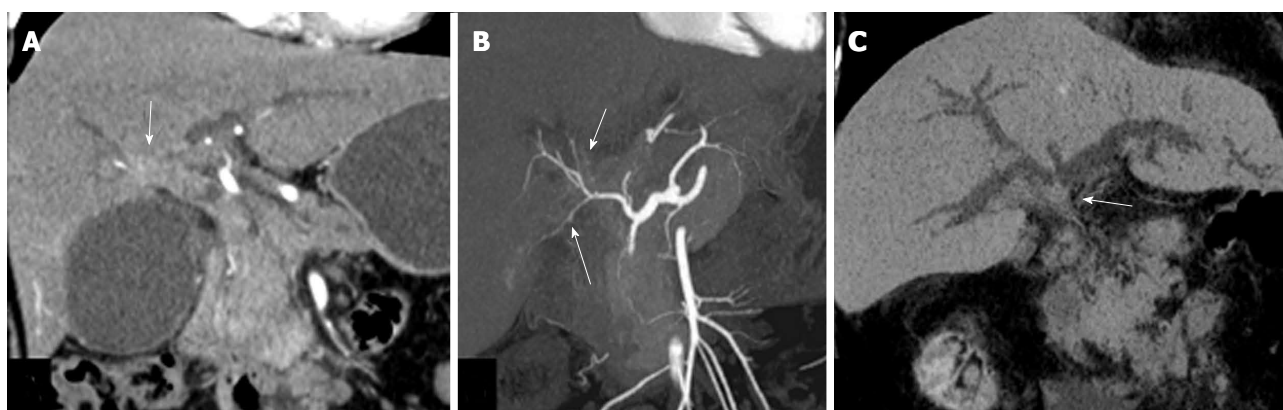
Post processing of computed tomography scan. A: Coronal reformat showing ill-defined enhancing mass (arrow) in relation to hilum and common hepatic duct; B: Coronal thick maximum intensity projection showing same mass as in A (short arrow) with irregularity of right posterior hepatic artery (long arrow); C: Minimum intensity projection showing the extent of biliary involvement by the mass (arrow).
